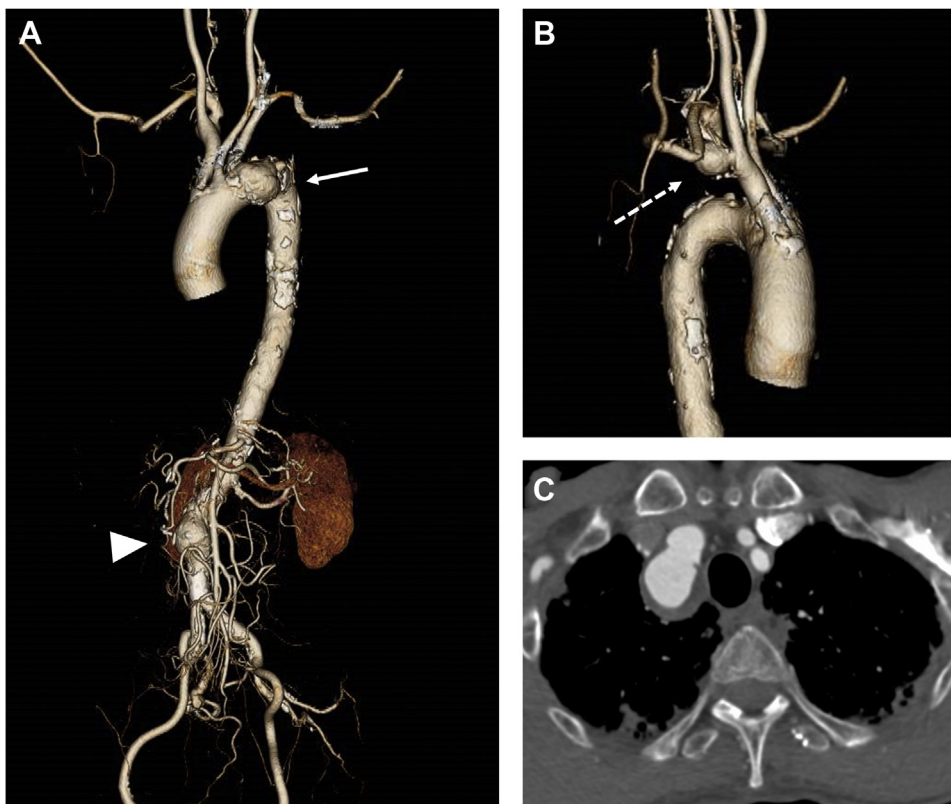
Preoperative computed tomography (CT) angiography. A, Reconstructed three-dimensional image of left oblique view. B, Reconstructed three-dimensional image of right oblique view. C, Axial image. These images show the thoracic aortic aneurysm (TAA; *white arrow*), abdominal aortic aneurysm (AAA; *white arrowhead*), and saccular right subclavian artery aneurysm (RSCAA), which was projecting posteriorly (*white dotted arrow*).
